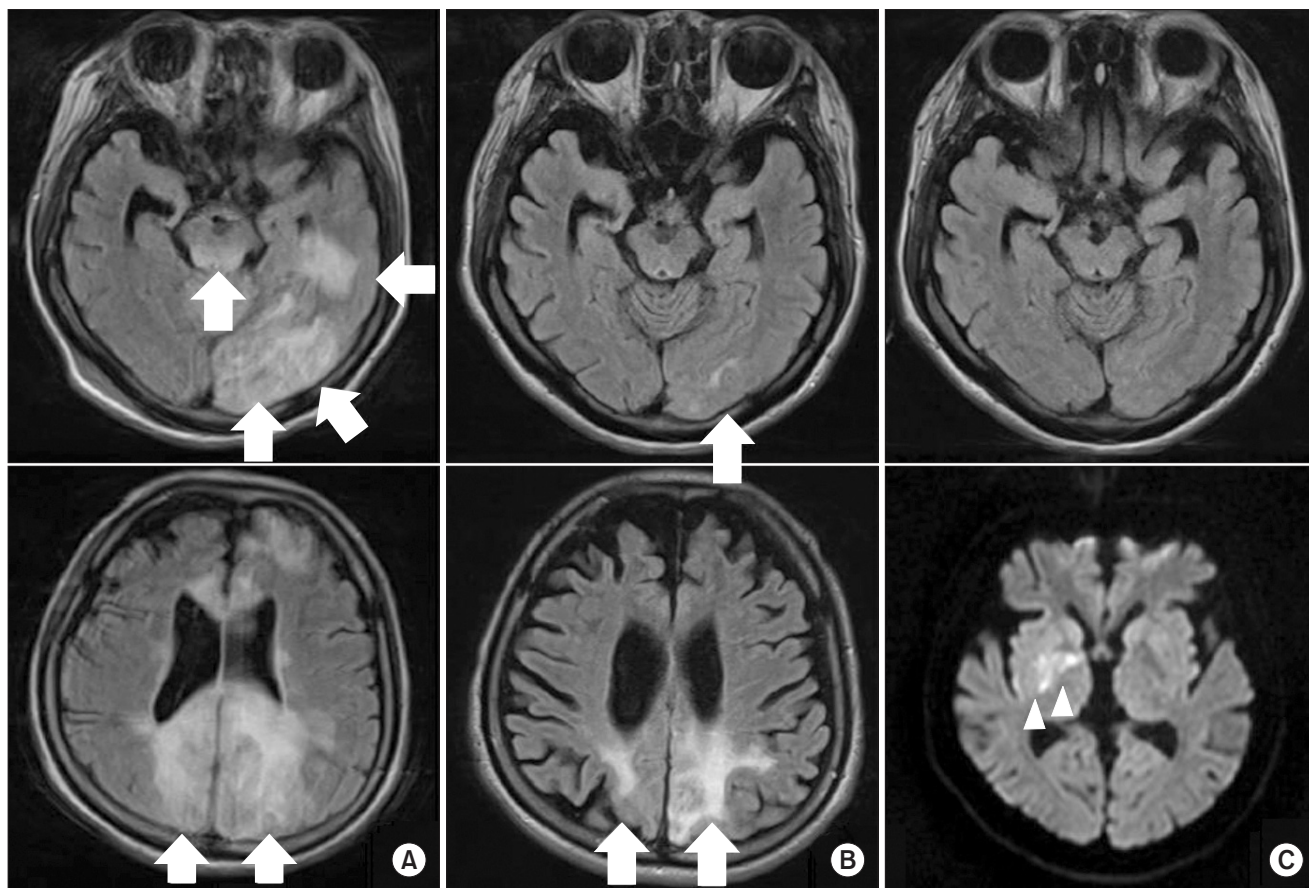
Sequential brain magnetic resonance images. A T2-fluid attenuation inversion recovery image shows multiple high-signal-intensity lesions in the left temporal and frontal lobes, both occipital lobes, and the midbrain (A). Fifteen days later, the previously noted lesions were markedly resolved (B). Although the previously noted lesions were completely resolved, acute right basal ganglia infarction (arrowheads, C) was seen on brain diffusion magnetic resonance imaging 1 week later.
